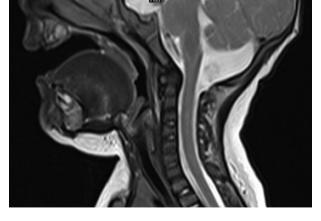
Sagittal MRI imaging of the craniocervcial region showed no Chiari-malformations and or syringomyelia
